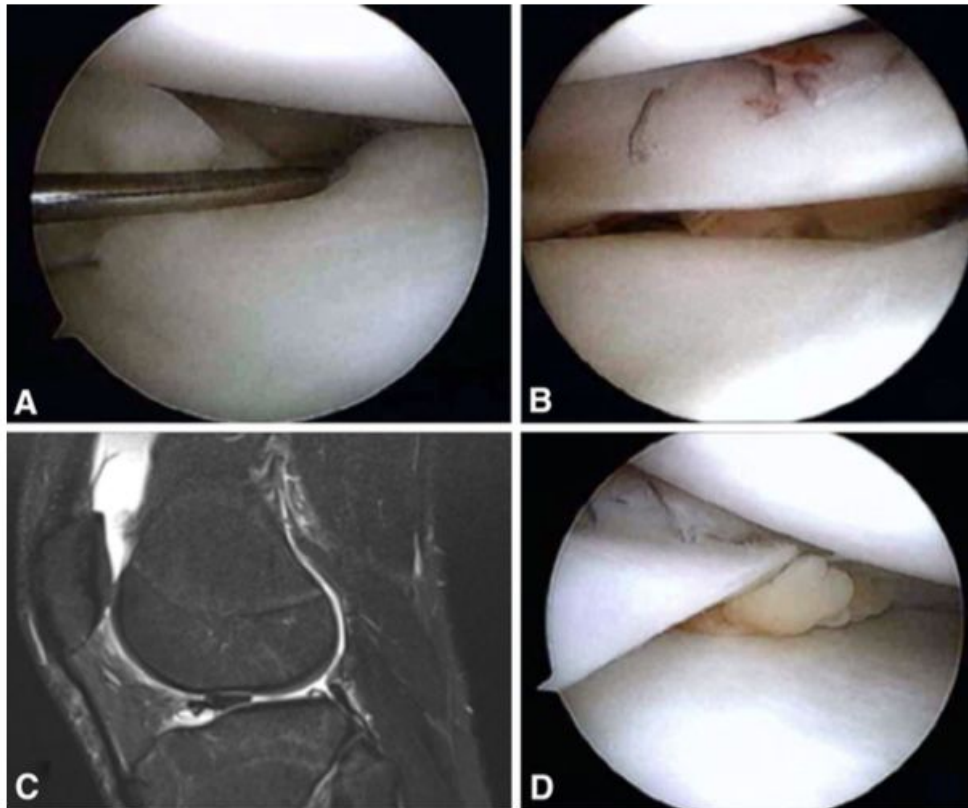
D (A) An intraoperative image of a displaced meniscus tear is shown. (B) An inside-out repair is performed with PRP augmentation. (C) MRI demonstrates a bucket-handle lateral meniscus tear and (D) PRP augmentation of this meniscus repair.
